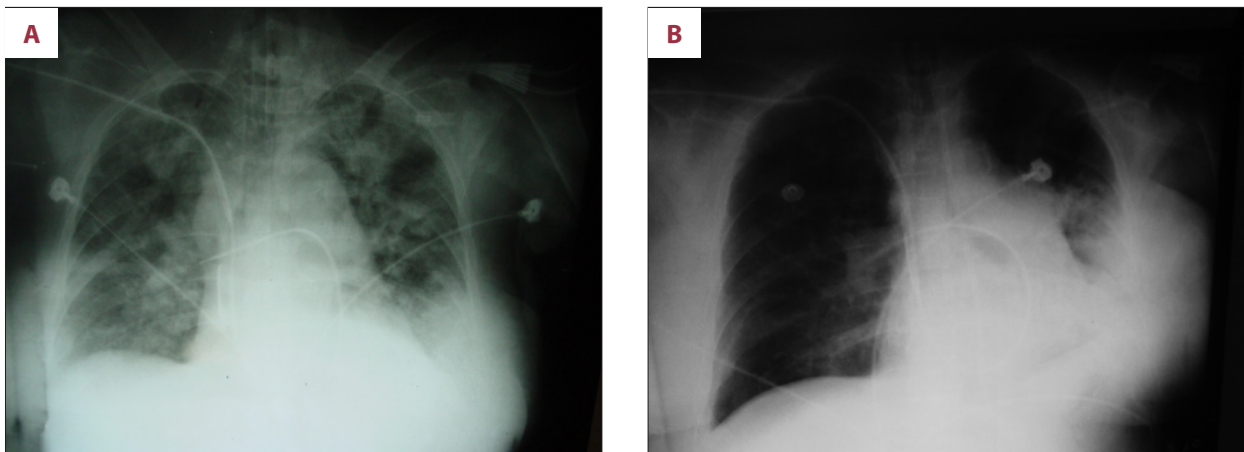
(A) Chest radiograph on postoperative day 3 showing diffuse bilateral infiltrates. (B) Chest radiograph on postoperative day 5 showing a nearly clear lung fields.
